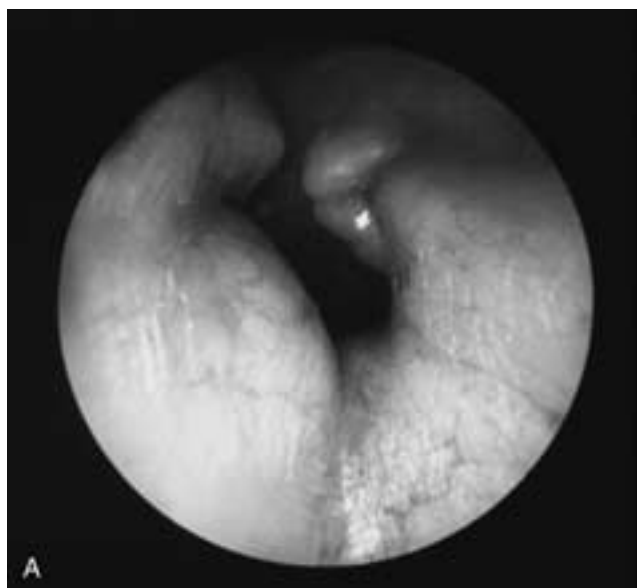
Exostosis in the EAC. A, Otoscopy. The EAC is nearly obliterated by multiple sessile exostoses. B, Axial CT image. Exostosis is a broad-based mass (arrow) in the EAC.
